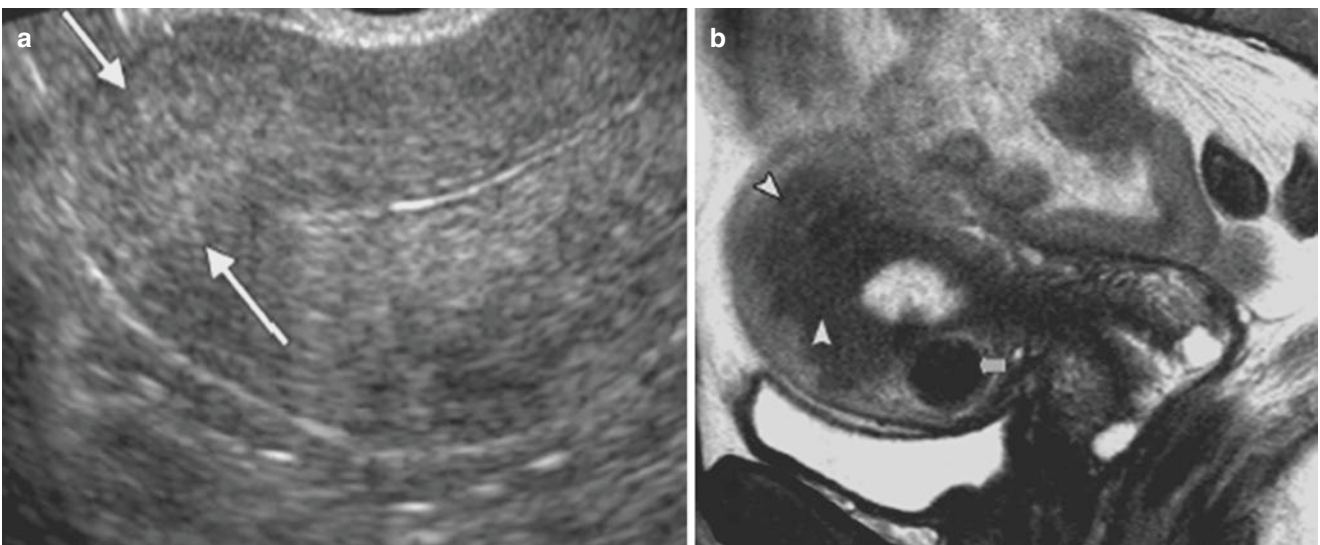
(a) Transvaginal ultrasonography. In the fundus, an area of focal heterogeneity can be seen, without significant volume or morphology changes. (b) Sagittal, TSE, T2 weighting. The area identified
